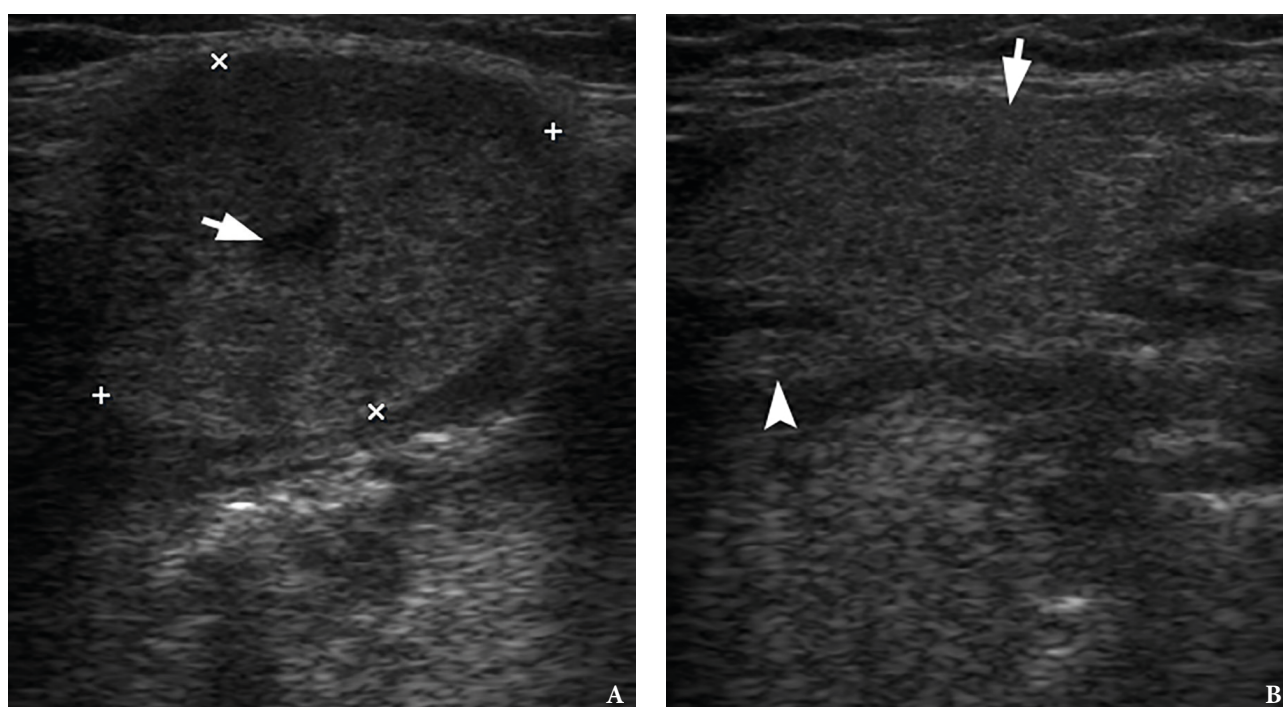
Comparison of the longitudinal gray scale sonograms of a right obstructed and inflamed submandibular gland (A) with a left nonsymptomatic gland (B). At image A, the gland is indicated by '+' and 'x' calipers. The gland is enlarged in size almost twice and has a rounded form. Note a dilatation of the intraglandular duct (*arrow*). At image B, the superficial (larger) lobe of the left nonsymptomatic gland is lying within the digastric triangle¹⁹ and is indicated by *arrow*, the deep (smaller) lobe – by *arrowhead*.
